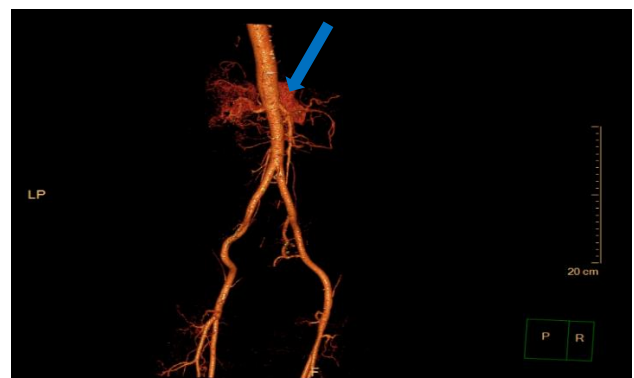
CT angiography (posterior) demonstrating the entire abdominal arterial vasculature (contained hematoma marked by arrows).
